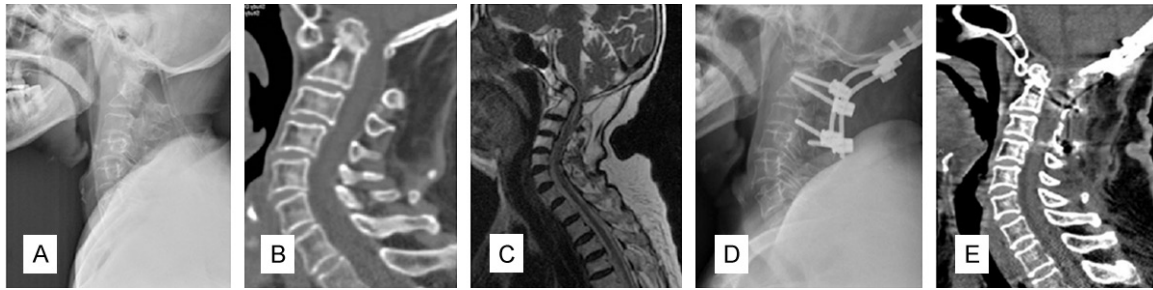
A: Preoperative X-ray; B: Preoperative CT reconstruction showed the dentate process obviously trapped upwards into the foramen magnum, and displaced backwards, and the spinal canal on the relative level was narrowed; C: Preoperative MRI showed that the cervical spine was significantly compressed; D: Postoperative X-ray: no loose or broken internal fixation; E: Postoperative CT reconstruction showed good reduction.
